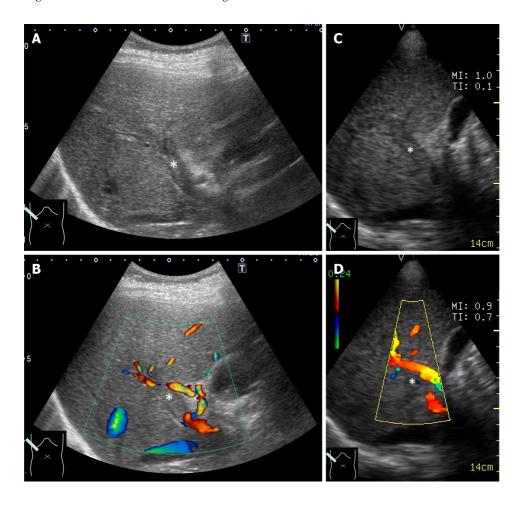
Simultaneous presentation of ultrasound images of a portal thrombus. A: High-end ultrasound B mode; B: High-end ultrasound color Doppler; C: Pocket-sized ultrasound B mode; D: Pocket-sized ultrasound color Doppler. These comparisons are used to understand the difference in image quality between the two machines. It also confirms that pocket-sized ultrasound is sufficient for diagnoses. *: Thrombus in the portal vein.
